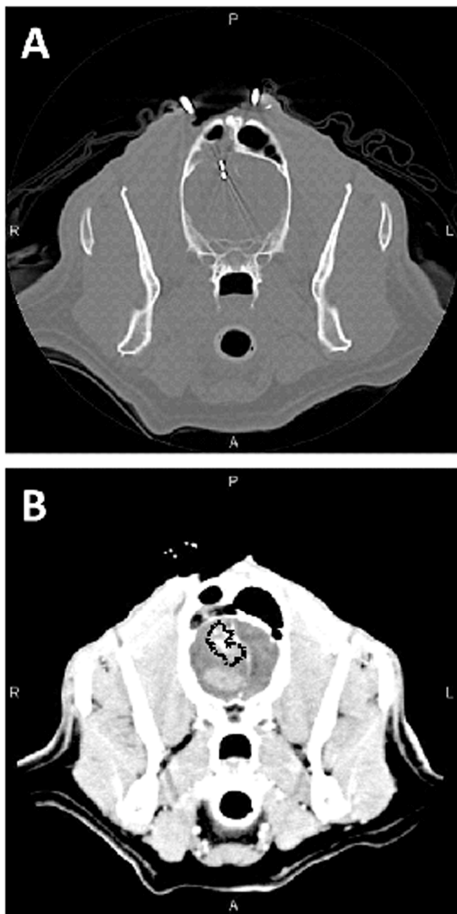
IRE procedure performed with CT-guidance A) electrode placement and B) treatment visualization.
